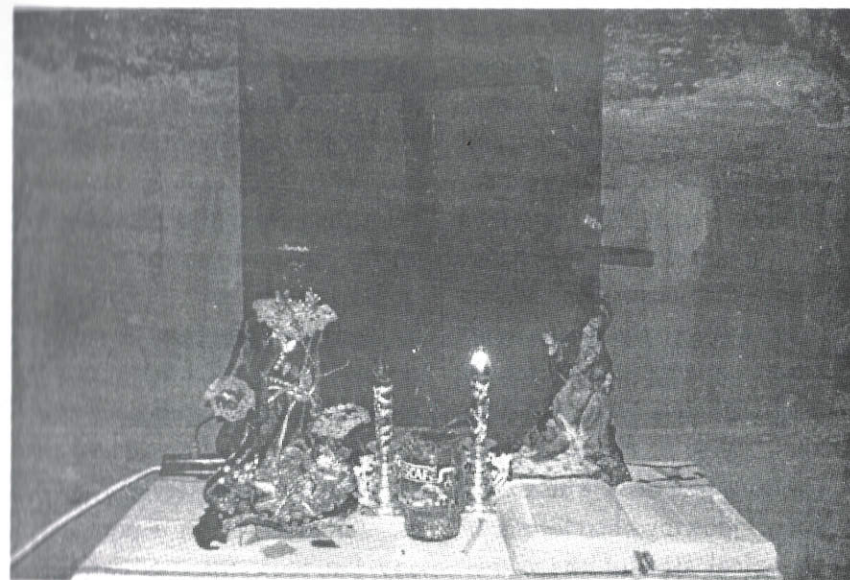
The "X-ray" altar of Mananambal E
